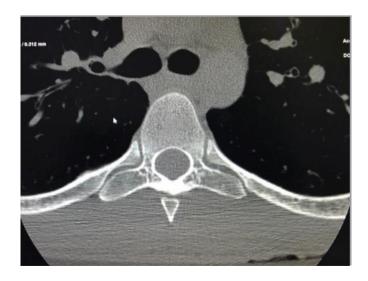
Costovertebral joints in CT image
